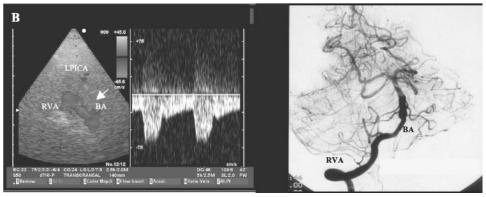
Transcranial color-coded sonography. (A) Severe proximal basilar artery (BA) stenosis. (B) Complete revascularization with flow normalization in the BA.
